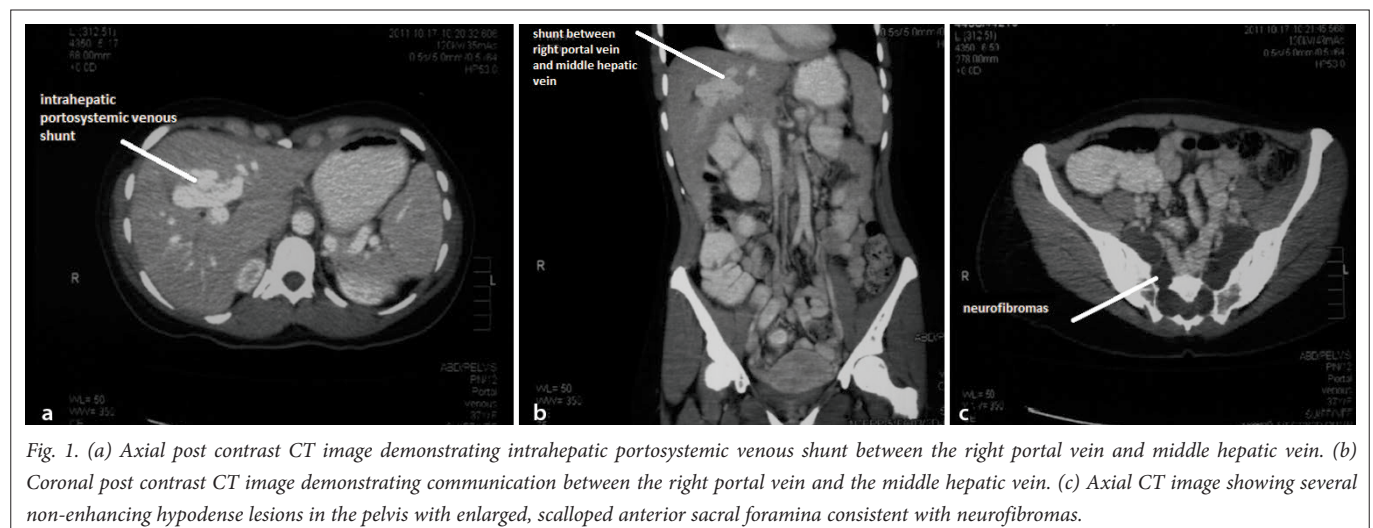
(a) Axial post contrast CT image demonstrating intrahepatic portosystemic venous shunt between the right portal vein and middle hepatic vein. (b) Coronal post contrast CT image demonstrating communication between the right portal vein and the middle hepatic vein. (c) Axial CT image showing several non-enhancing hypodense lesions in the pelvis with enlarged, scalloped anterior sacral foramina consistent with neurofibromas.
